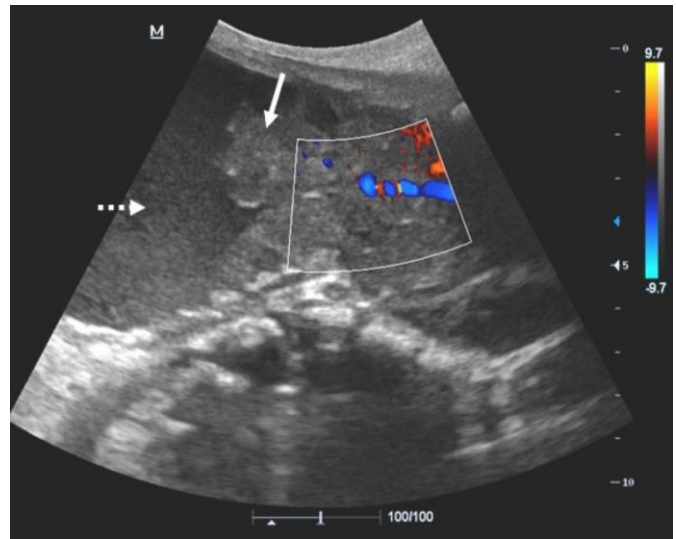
Longitudinal duplex ultrasound of the urinary bladder showing an irregular, heterogeneous, polypoid, vascular mass (solid arrow) projecting into the urinary bladder lumen from the region of the trigone; Mobile low-level echoes noted within the bladder (dashed arrow)
